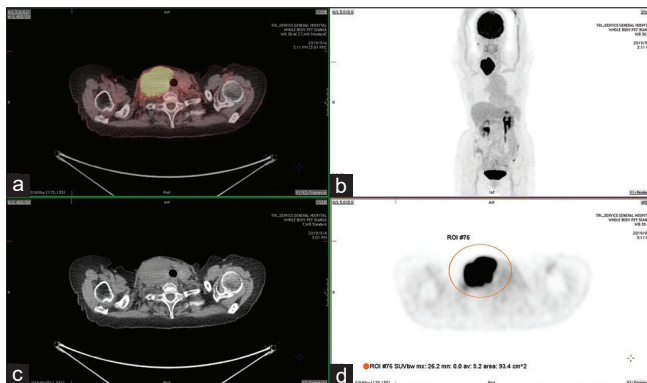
The fluorodeoxyglucose positron emission tomography computed tomography scan (left) reveals a tumor with high-grade hypermetabolic status in the right lobe of thyroid gland. The whole-body positron emission tomography scan (right) shows no other foci with increased fluorodeoxyglucose uptake out of the thyroid gland. Therefore, the primary thyroid lymphoma is diagnosed based on the pathological result from core needle biopsy
